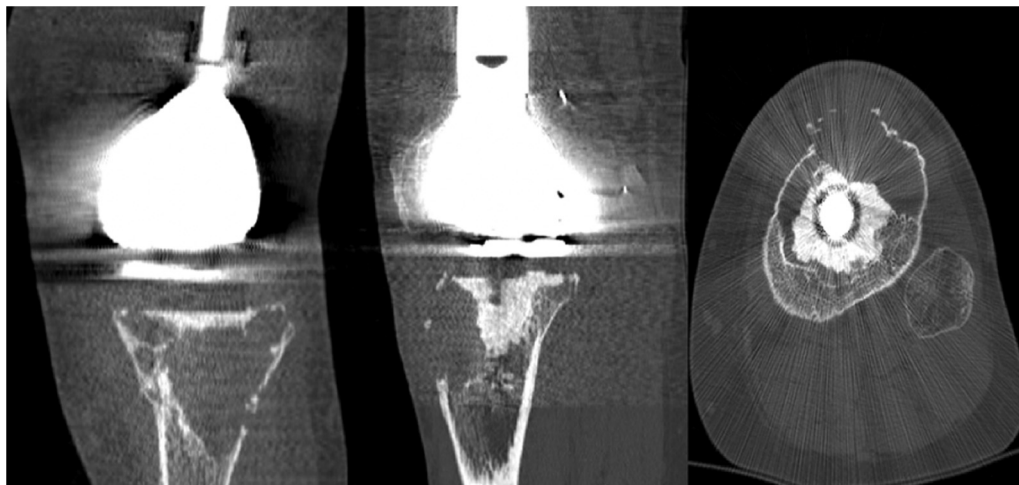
Patient A, left knee. CT images showing a periprosthetic osteolytic lesion breaching the anterior cortex and extending to the bone-cement interface.
